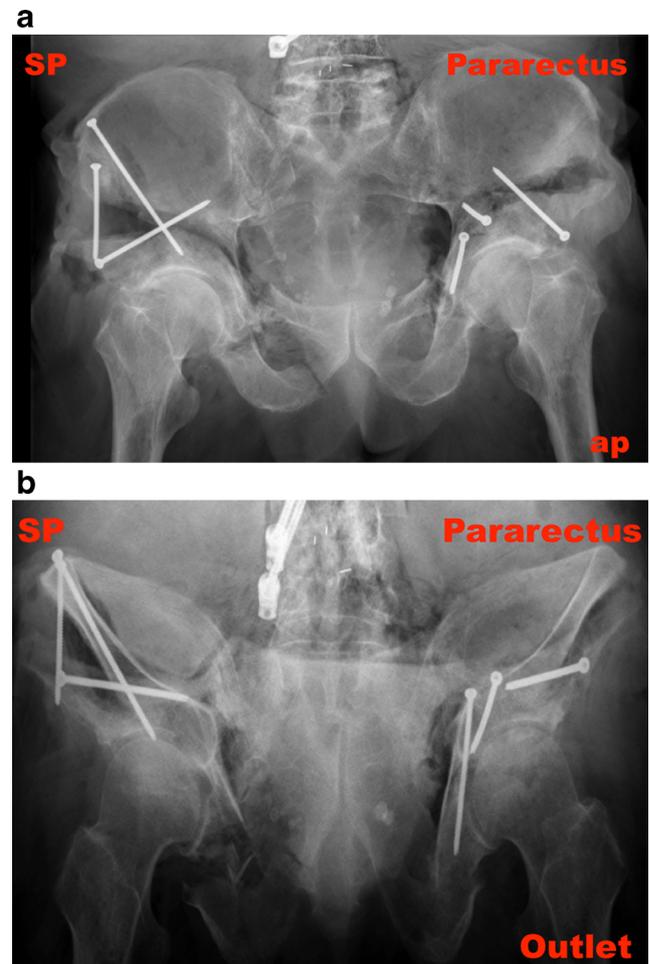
Fragment fixation is depicted on an anteroposterior and outlet pelvis X-ray. The right hip was operated through a modified Smith-Petersen (SP) approach and the left hip through the pararectus approach, in which new screw trajectories were evaluated. Finally, safe corridors were determined for one screw into the posterior column through the infra-acetabular bone corridor, whereas two other screws found reliable purchase within the supra-acetabular bone stock
